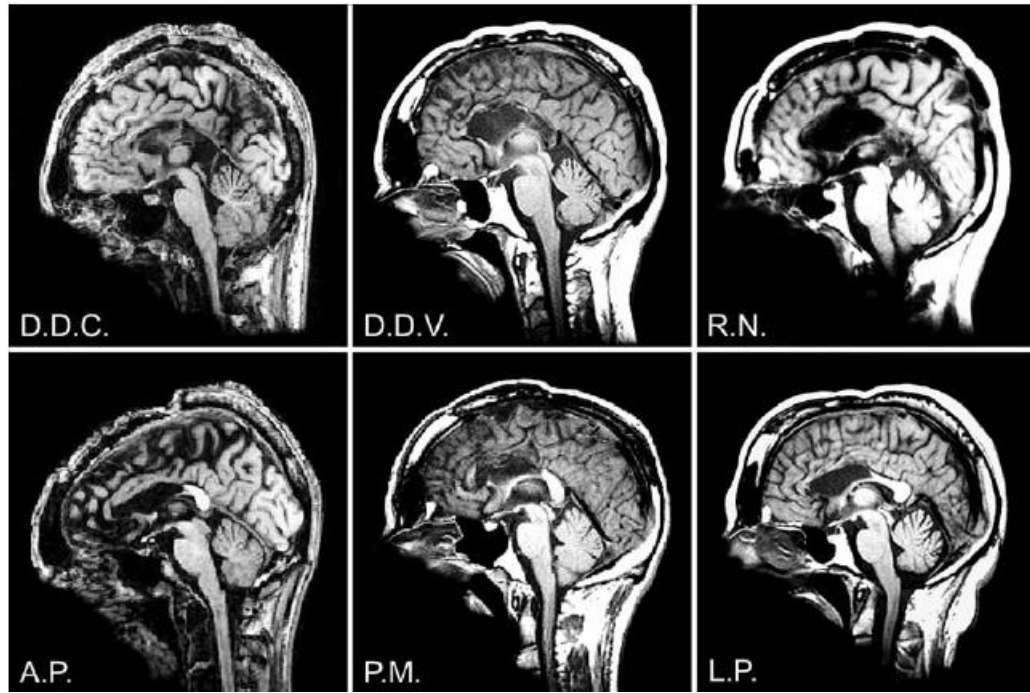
MR images of midsagittal brain slices obtained from T1-weighted spin-echo sequences showing the extent of callosal resection in 6 patients (Fabri et al. 2005).
